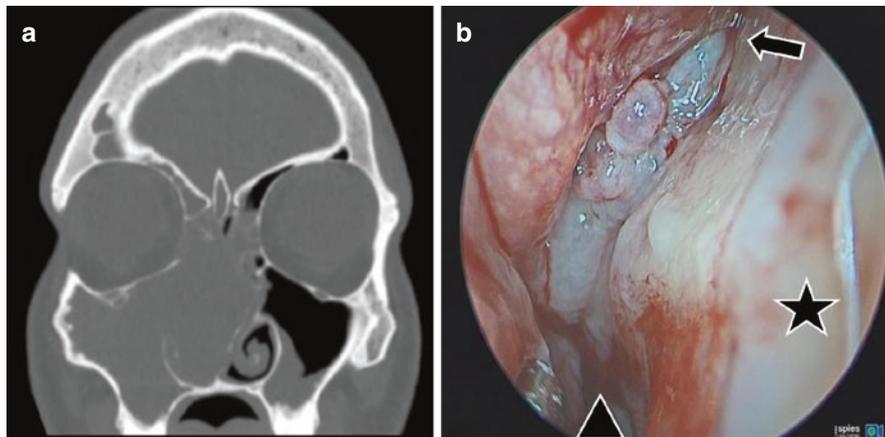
(a) Coronal CT scan of sinonasal squamous cell carcinoma with extensive involvement of the nasal septum, and (b) clival chordoma with intranasal extension and direct tumor contamination of right nasoseptal flap pedicle (star = nasal septum; triangle = arch of right choana; arrow = os of right sphenoid sinus)
